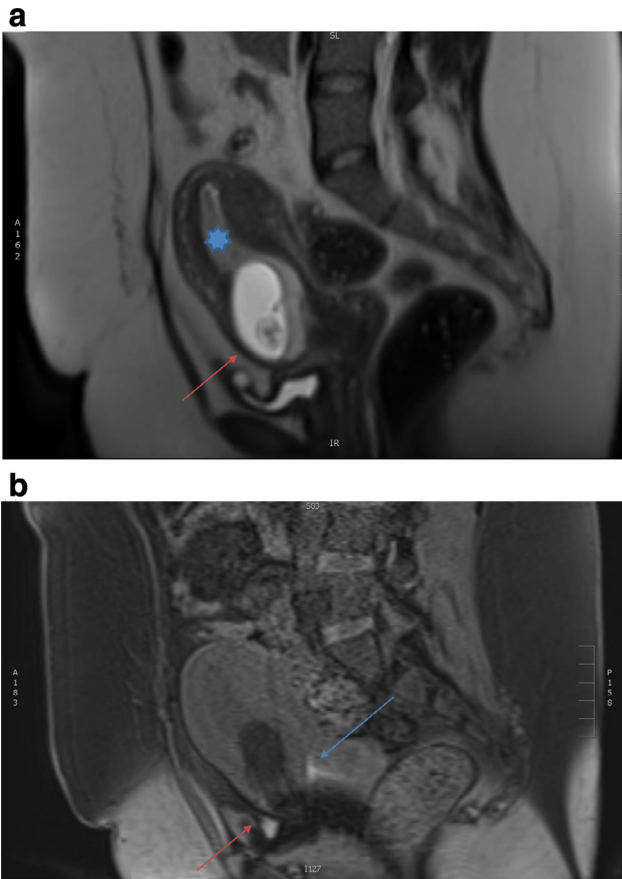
(a) Sagittal T2-weighted imaging demonstrating thinning of the anterior myometrium with low T2 signal (red arrow) and empty endometrial canal (*). (b) Sagittal T1 fat suppressed imaging demonstrating T1 hyperintense material in the pelvis (red arrow) and cervix (blue arrow) indicative of blood products.
